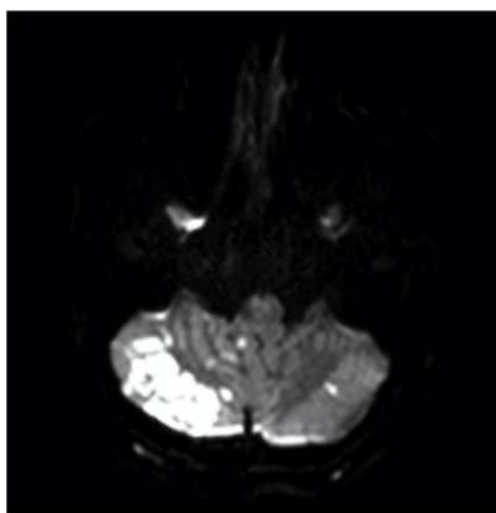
Axial, diffusion-weighted imaging (DWI) magnetic resonance imaging (MRI) for Patient 1. Revealing acute infarcts in both cerebellar hemispheres and in the medulla oblongata.
